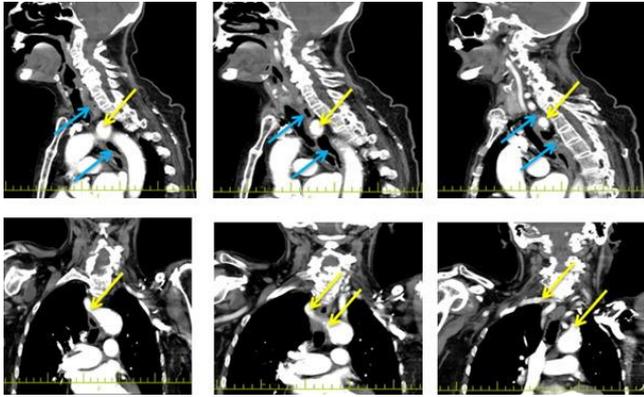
The aberrant right subclavian artery (yellow arrow) and compressed esophagus (blue arrow) on sagittal (top) and coronal (bottom) CT scans of the patient
